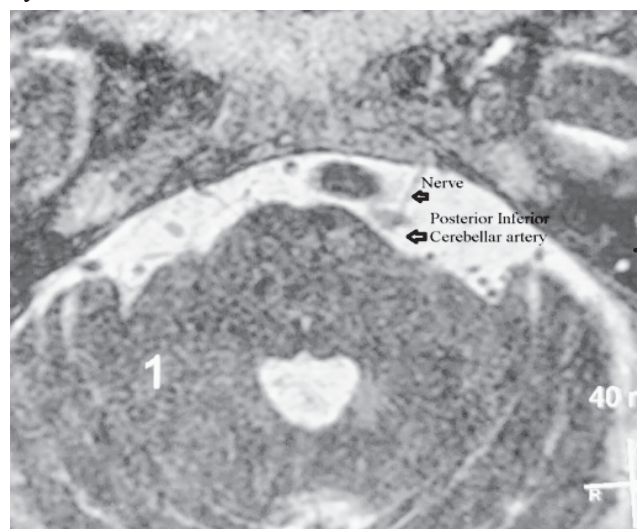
Axial 3D T2 Drive MR image.
